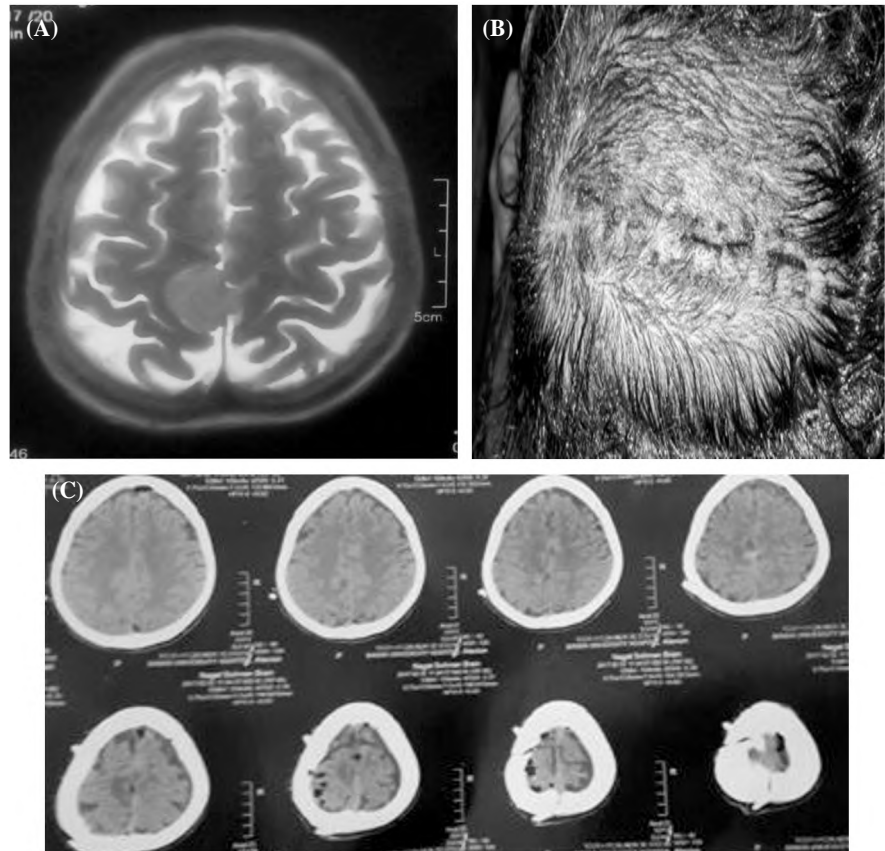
(A), Pre-operative axial MRI T II showing right sided parasagittal meningioma. (B), Picture taken after removal of stitches with good wound outcome. (C), Post-operative CT brain showing complete tumor removal.
